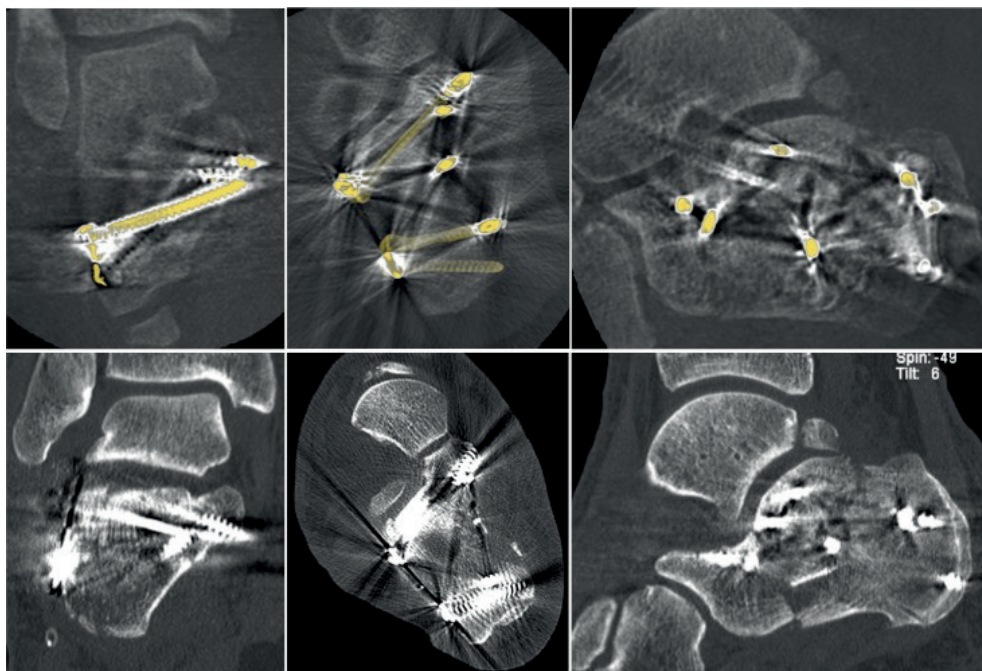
Intra-operative 3D-reconstructions and postoperative CT-scan
